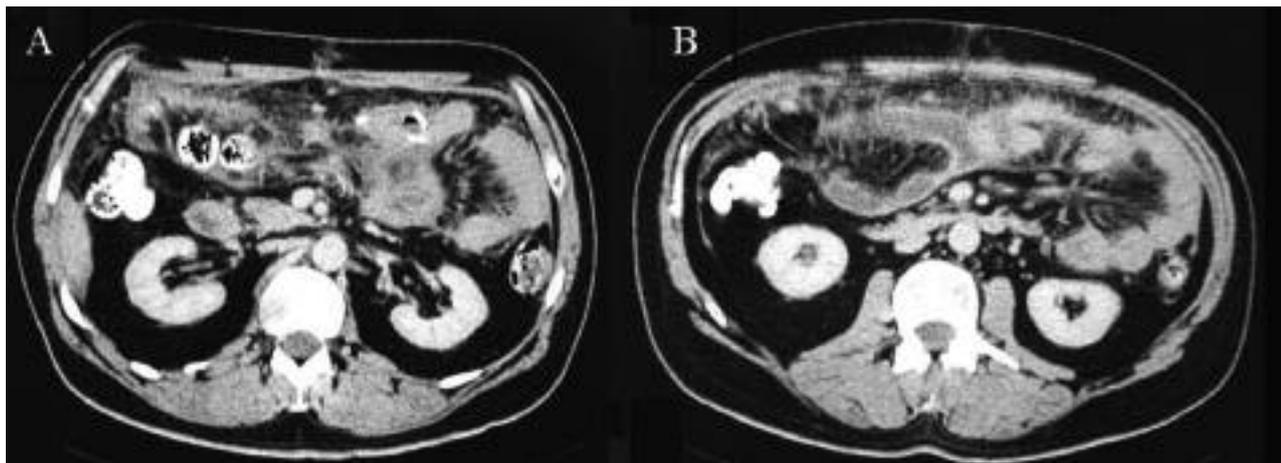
CT scan showing A : wall thickening of a small intestine segment and B : infiltration of the mesentery and the peritoneal adipose tissue.
